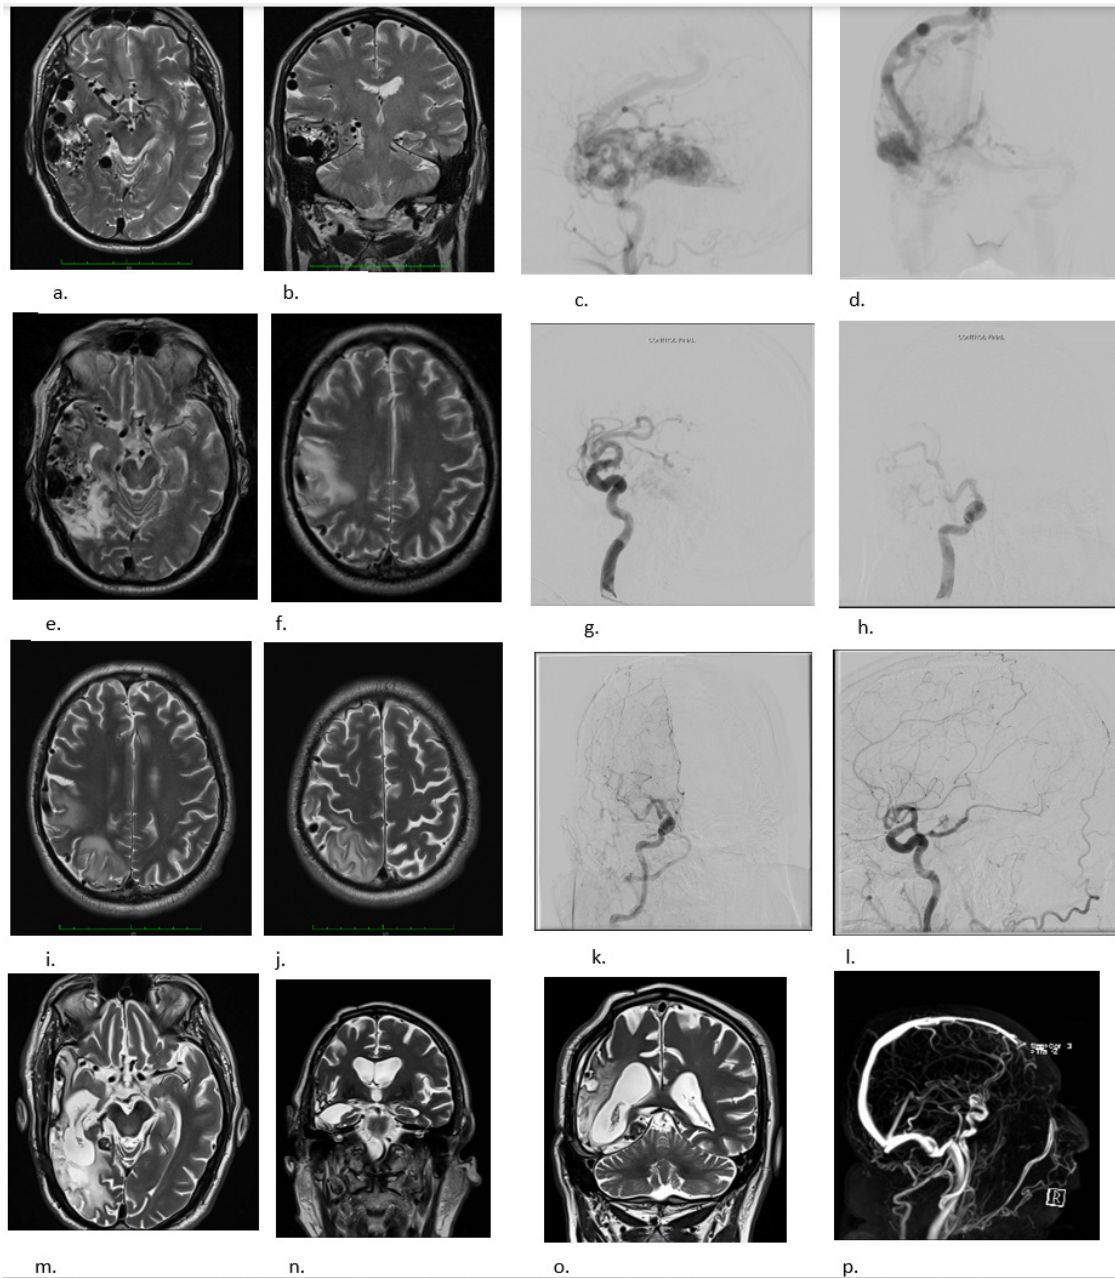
(a-b) MRI (2018) T2-weighted axial and coronal views: non-ruptured right temporal AVM; (c-d) Diagnostic angiography (2018) showing an unruptured right temporal AVM (45mm in diameter) with afferents from the temporal branches of the PCA and right MCA; outflow aneurysm in the right temporal branch of the PCA, Spetzler Martin 3; and mixed superficial and deep venous drainage; (e-f-i-j) MRI (2019), T2-weighted coronal view showing extensive partially embolized right temporal AVM, with areas of temporal cortical and right parieto-occipital necrosis, and thick surface drainage veins. T2 signal alteration in the right frontoparietal region that could correspond to vasogenic edema (flow dynamics); (g-h) Post embolization angiography (05/2019): Embolized AVM with total exclusion; (k-l) Postoperative angiography (08/30/2021): Complete exclusion of right temporo-occipital AVM after embolization and surgery; (m-n-o) T2-weighted, axial and coronal views of the surgical bed with temporal resection of the AVM and cortical disconnection of the central sulcus (p) Last MR angiography reveals a complete exclusion of AVM.
